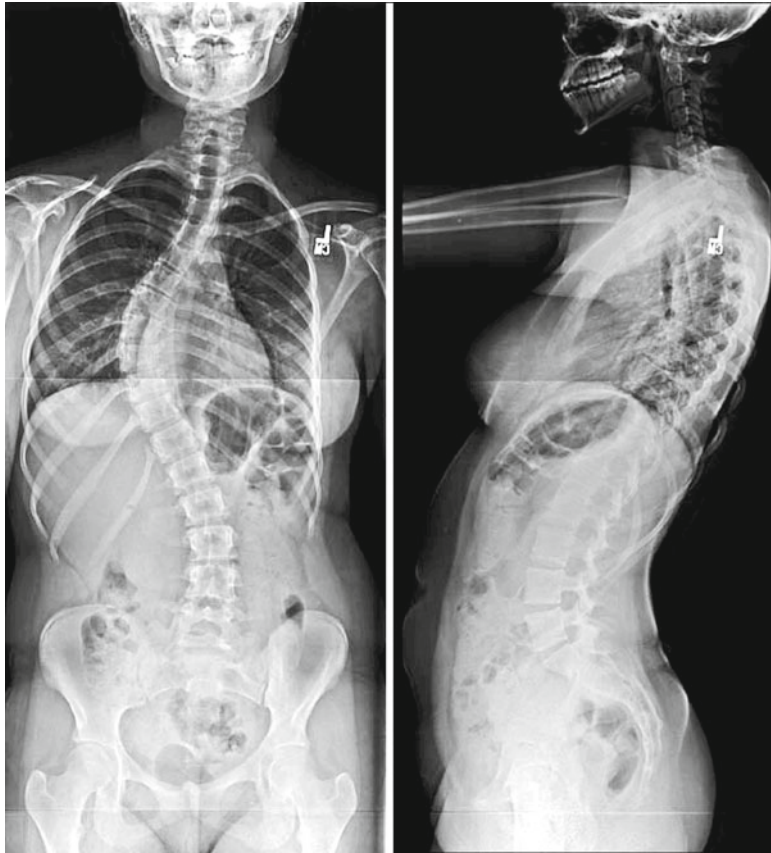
Standing PA and lateral thoracolumbar spine X-rays demonstrating thoracic scoliosis. Asymmetry of the ribcage can be appreciated, demonstrating the rotational component of the deformity
